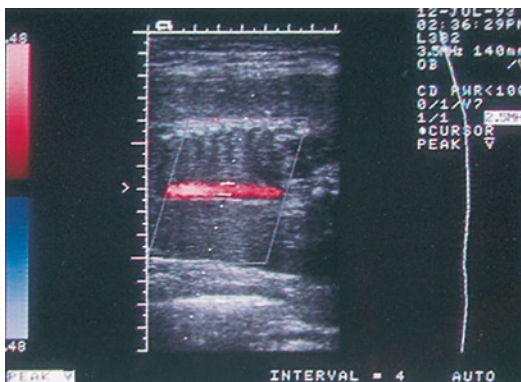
Examination of the fetal descending aorta with a linear array duplex system. The color Doppler box and the pulsed Doppler beam are inclined; the insonation angle is still high
